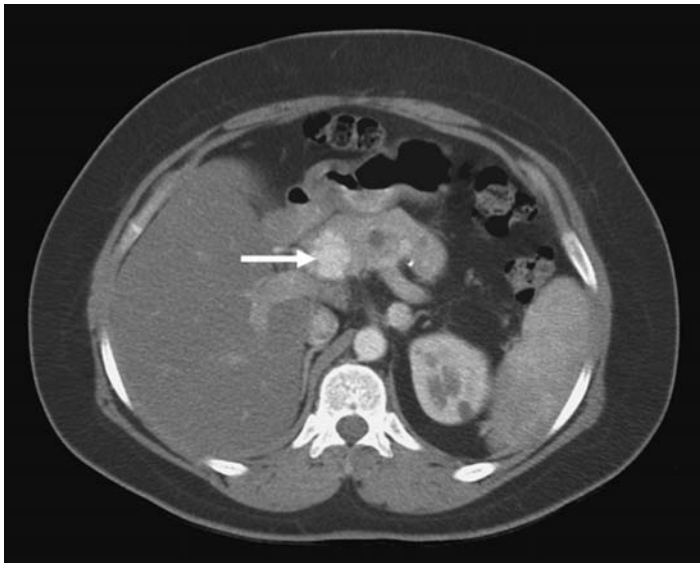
CT Abdomen in a patient with von Hippel–Lindau syndrome showing a pancreatic neuroendocrine tumor (arrow) in the head of the pancreas, enhancing intensely after contrast media administration.
